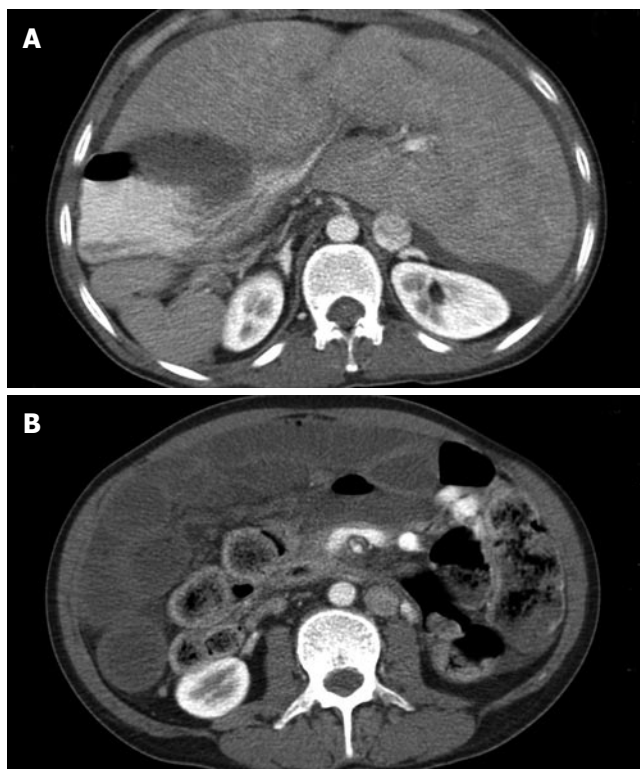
CT Scan imaging showing (A) situs inversus (note liver on the left and stomach on the right side) and (B) free intraperitoneal air.
